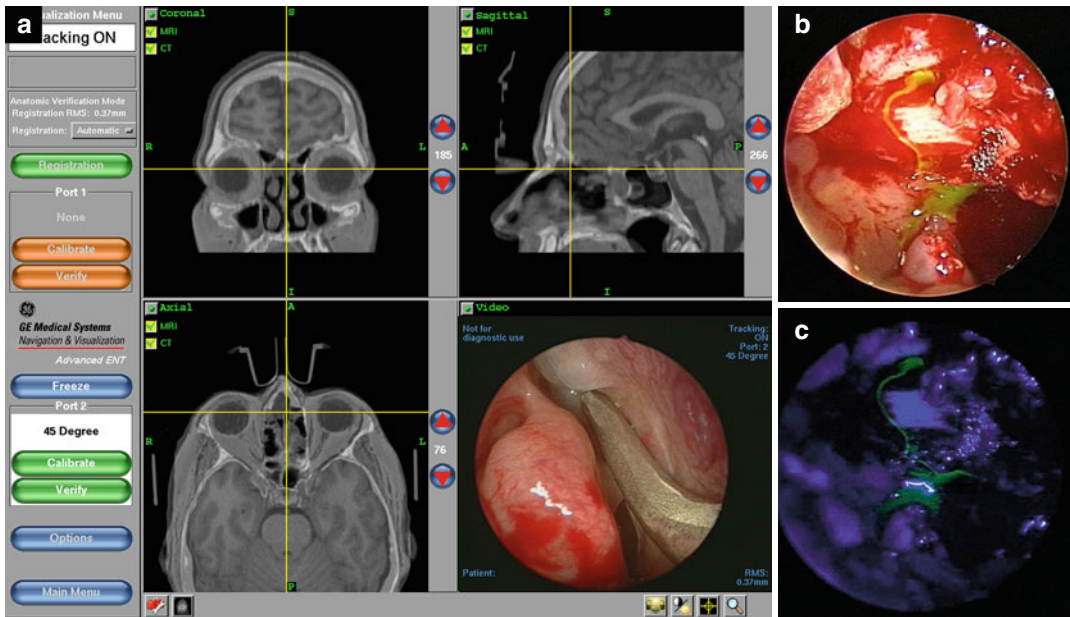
(a) Representative figure demonstrating an intraoperative stereotactic system that displays the standard orthogonal views based on the preoperative MRI scan. A trajectory view or the intraoperative endoscopic high-definition video feed can be displayed also to cross correlate the anatomy. (b, c) Intraoperative view in a
